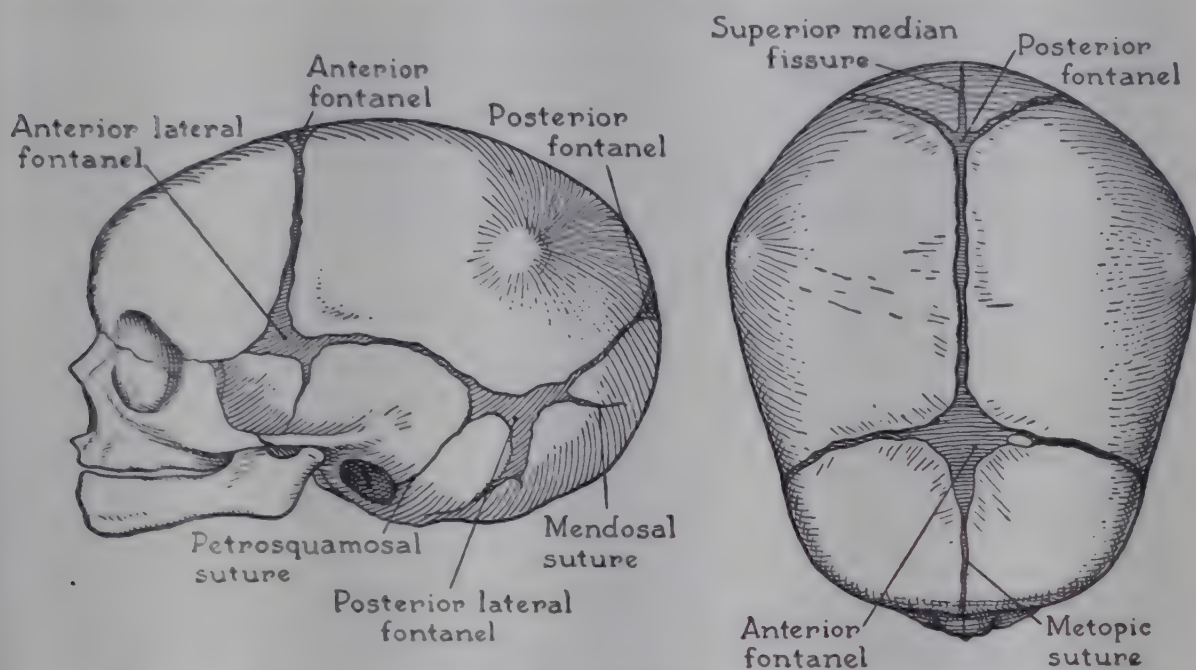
The cranium at birth, showing major sutures and fontanels. No attempt is made to show molding or overlapping of bones which sometimes occurs at birth. (From Caffey, J.: *Pediatric X-Ray Diagnosis* [2d ed.; Chicago: Year Book Publishers, Inc., 1950].)
